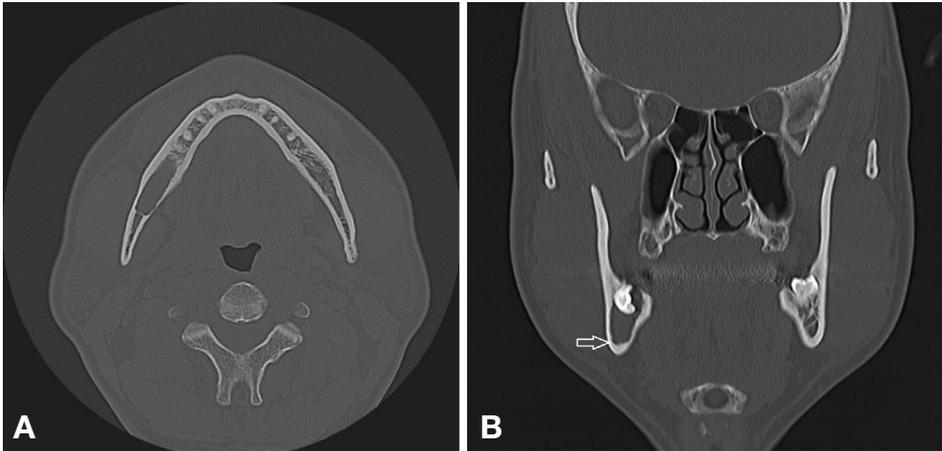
Computed Tomography view of pre-operative axial (A) and coronal views (B): The arrow in coronal view (B) indicates the location of the inferior alveolar nerve.
